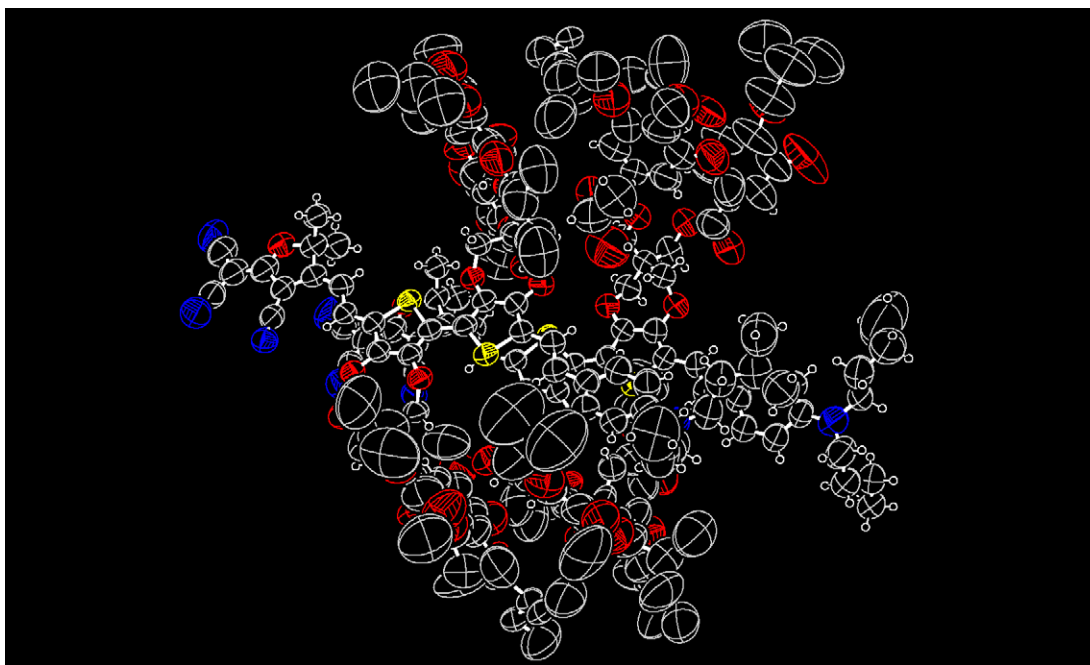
ORTEP view of synchrotron X-ray structure of SJLD-1
